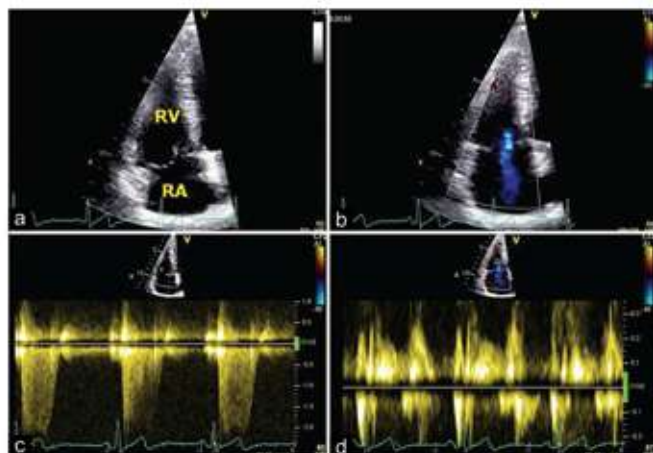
An right ventricle focused view obtained from the apical 4-chamber view; (a) two-dimensional image, (b) with color showing tricuspid regurgitation jet, (c) tricuspid regurgitation jet assessed by continuous-wave Doppler, (d) flow across the tricuspid valve assessed by pulsed-wave Doppler. RA- right atrium, RV- right ventricle
